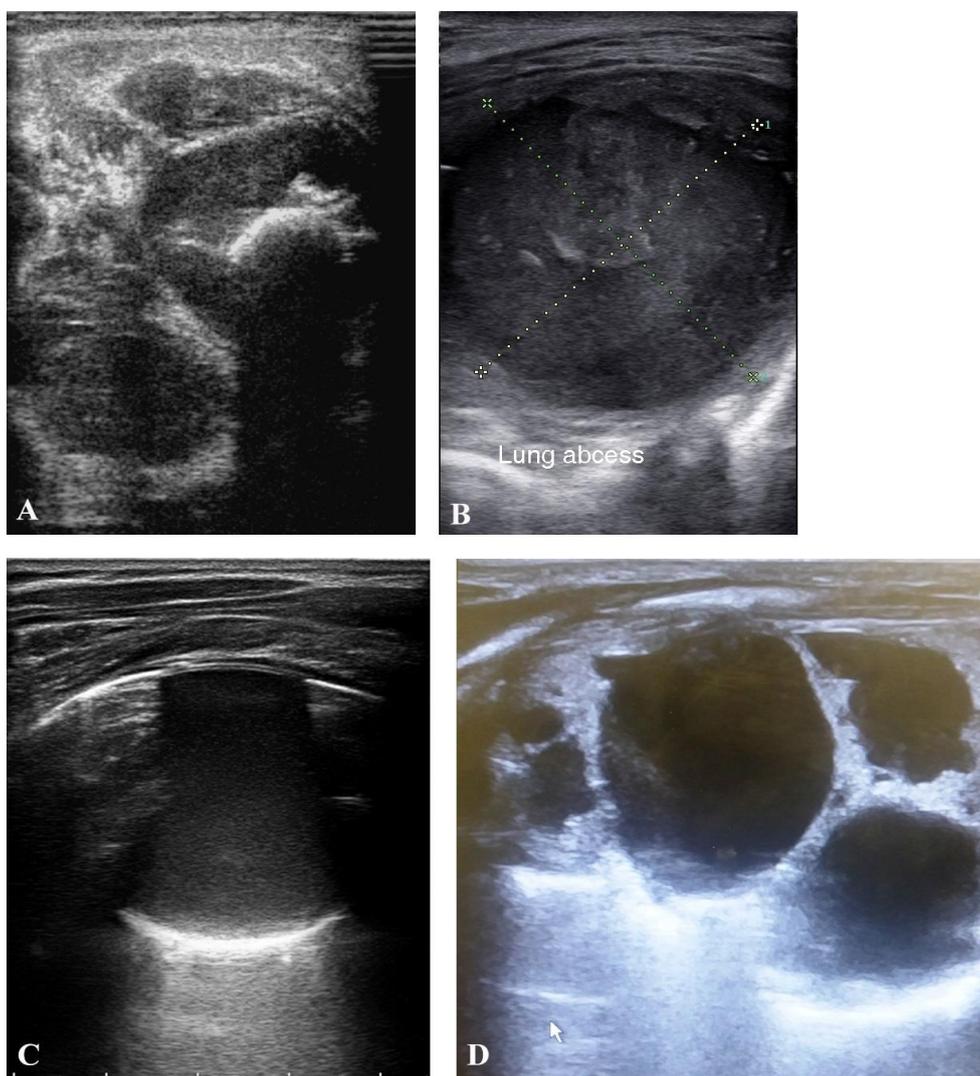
The ultrasound images of thoracic masses. A) Chest wall mass with rib origin as an eccentric heterogeneous mass with rib periosteal reaction. B) Lung abscess as a hypoechoic necrotic oval associated with plural thickening. C) The ultrasonic view of simple hydatid cyst of lung. D) A complex multi-cystic solid lung mass compatible with congenital pulmonary airway malformation (CPAM).
